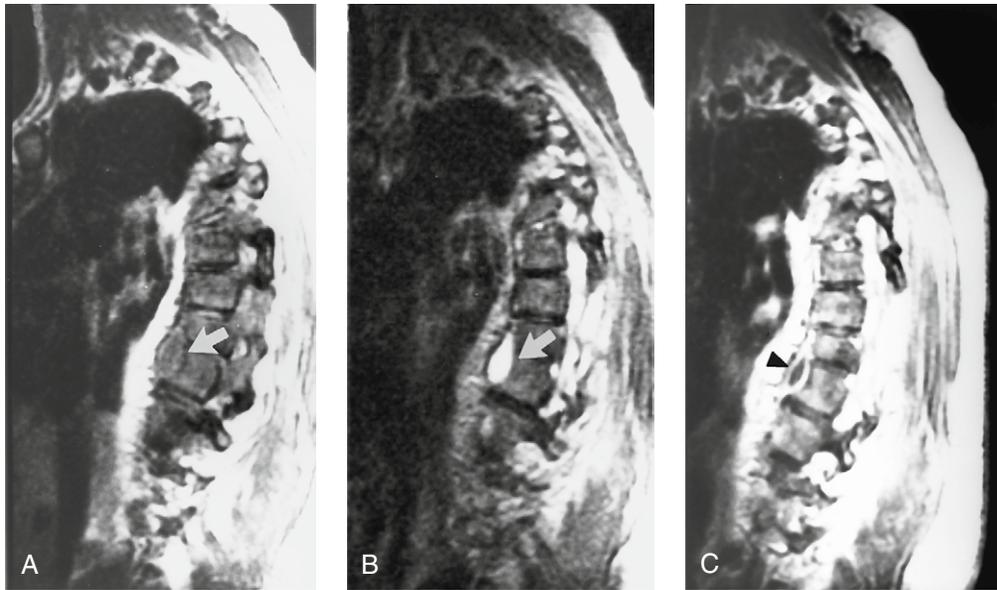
Blastomycosis paravertebral abscess. (A) Thoracic spine T1-weighted image shows a paraspinal blastomycosis abscess which has an isointense center and a slightly hyperintense periphery (white arrow). (B) Sagittal T2-weighted image shows hyperintense abscess (white arrow). (C) Sagittal T1-weighted image with gadolinium shows rim enhancement of the abscess (arrowhead).
